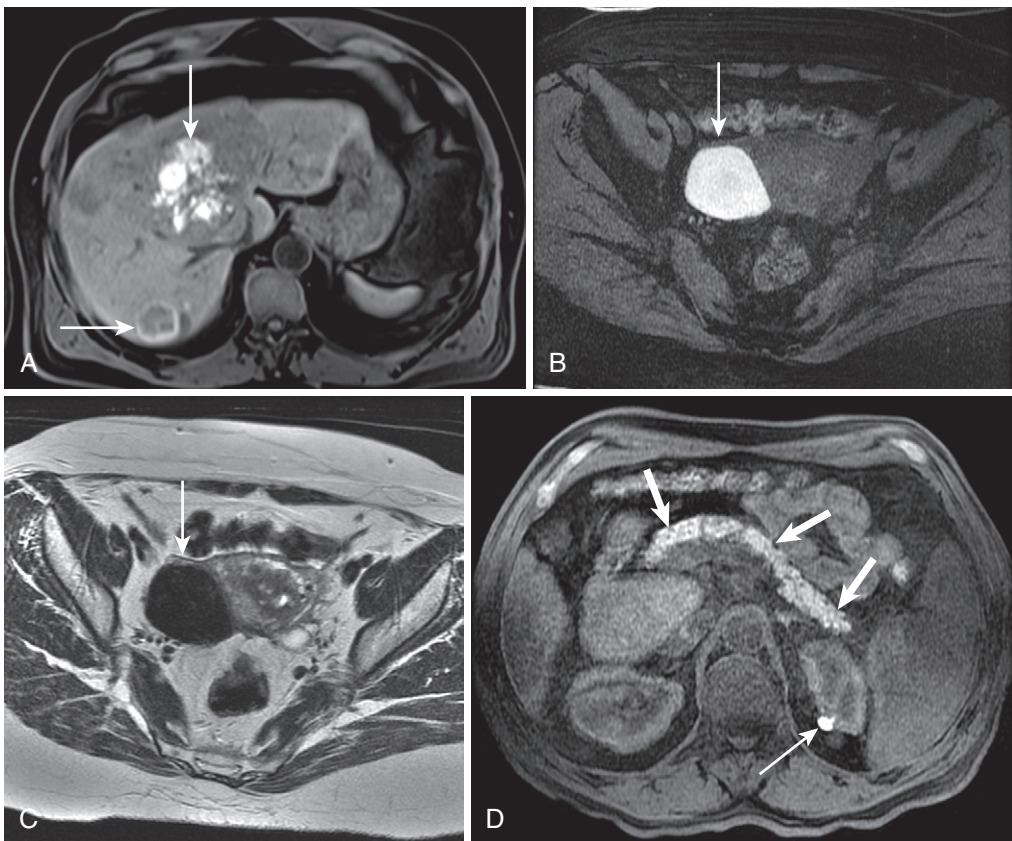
Precontrast imaging shows paramagnetic substance. A, The precontrast fat-suppressed (paramagnetic) image in a patient with metastatic uveal melanoma shows multiple, variably hyperintense lesions (*arrows*) reflecting variable melanotic content. B, A paramagnetic image in a patient with pelvic pain shows a large, irregularly shaped lesion with significant paramagnetism (*arrow*) due to hemorrhage. C, Marked hypointensity on the T2-weighted image characterizes the concentrated blood products found in an endometrioma (*arrow*). D, A paramagnetic image in a different patient shows the paramagnetic effects of a small left renal hemorrhagic cyst (*thin arrow*) and enzymatic proteins in the pancreas (*thick arrows*), causing these structures to be relatively hyperintense.
